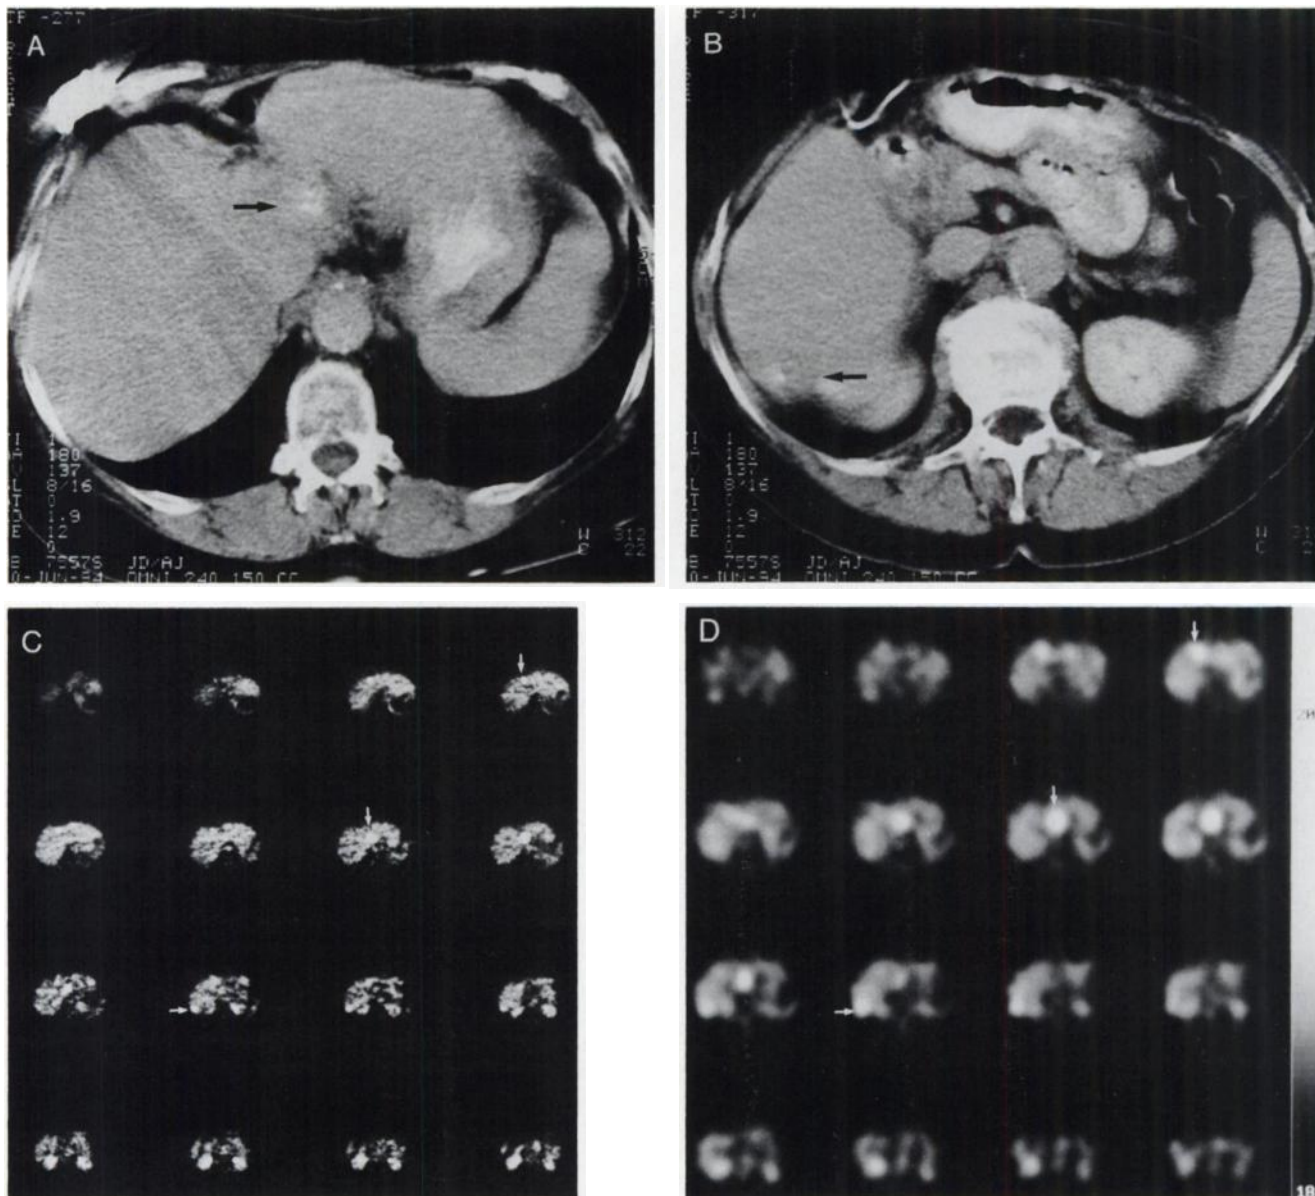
A 66-yr-old woman with colon carcinoma metastatic to the liver and prior partial hepatectomy. (A,B) CT scans show two lesions (arrows) with calcification in the liver (2 cm, 2.7 cm). (C) ^{18}F FDG-PET: transaxial images of the liver show increased uptake corresponding to the two lesions scanned on CT plus an additional lesion in the region of her prior resection (arrows). SUV 4.5–6.7. (D) ^{18}F FDG-SPECT: transaxial images of the liver show three hypermetabolic lesions.
